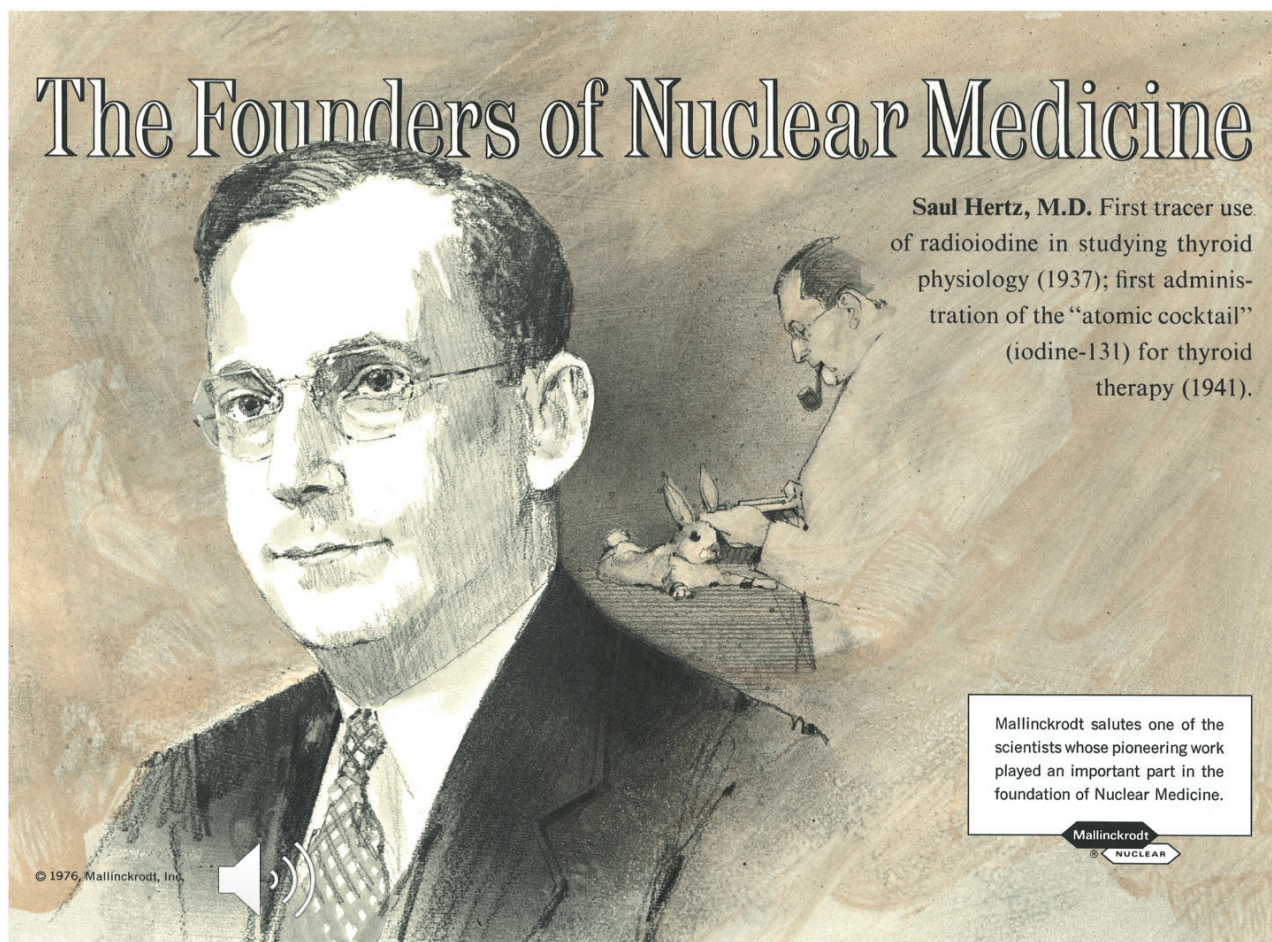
Mallinckrodt Commemorative Poster. Courtesy: Dr. Saul Hertz Archives Greenwich, CT USA..
